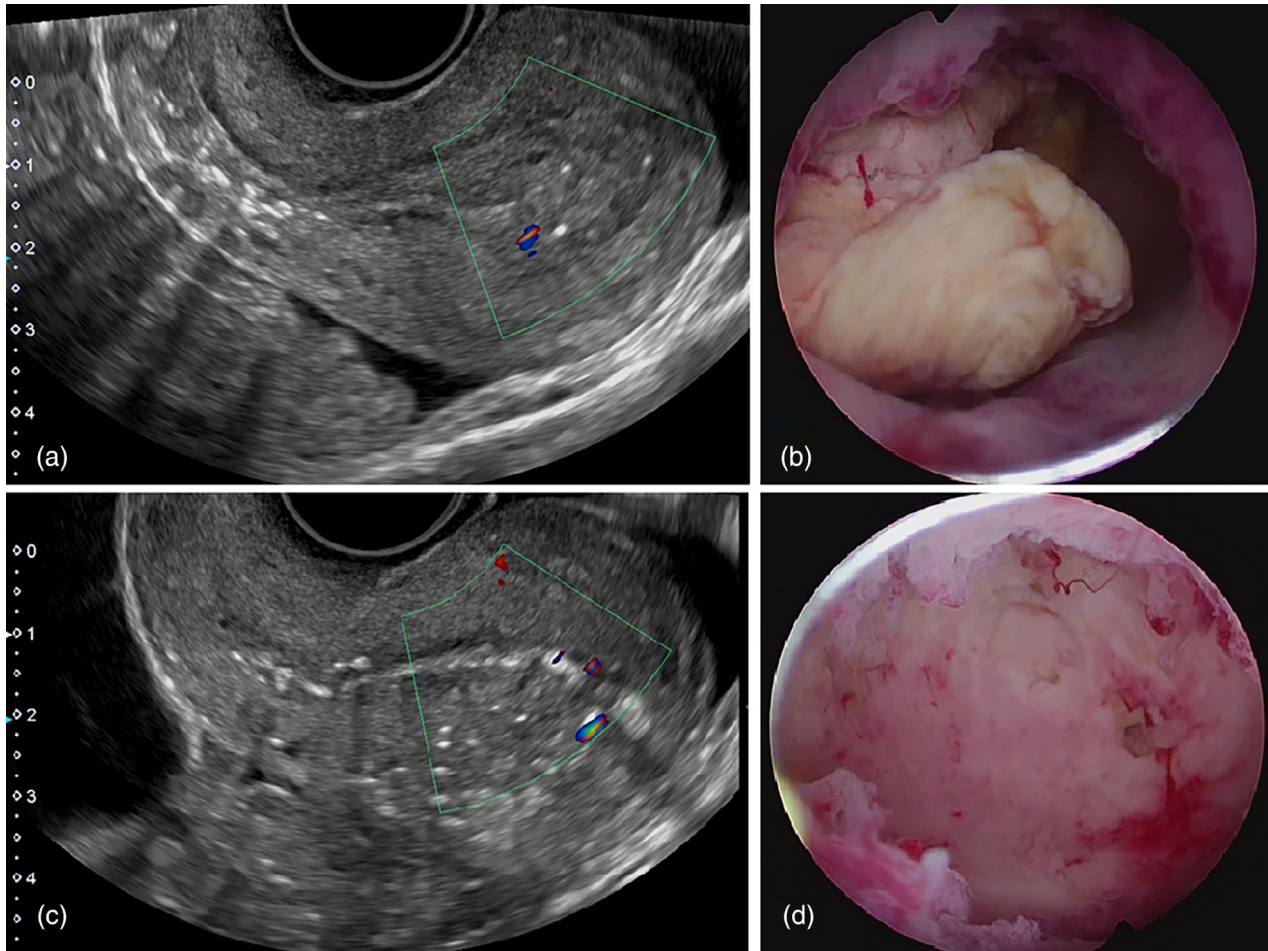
Hysteroscopic and postoperative ultrasound images. (a) Transvaginal color Doppler ultrasound after balloon dilation. Decreased blood flow can be seen. (b) Hysteroscopy shows a mass protruding into the uterus. (c) Transvaginal color Doppler ultrasound shows no abnormal blood flow and disappearance of the retained products of conception. (d) The mass was resected without bleeding using a resectoscope
